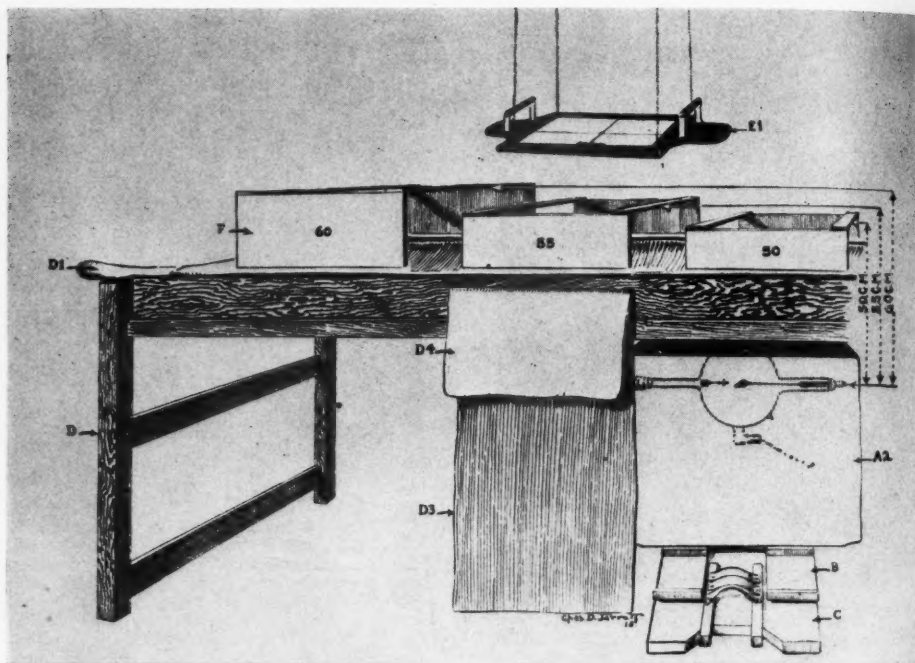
Focal skin plate or cassette holders for double exposure localization or radiographic examination technic when the floor trochoscope is employed. For convenience 50-55-60-cm. focal plate distances are employed.
